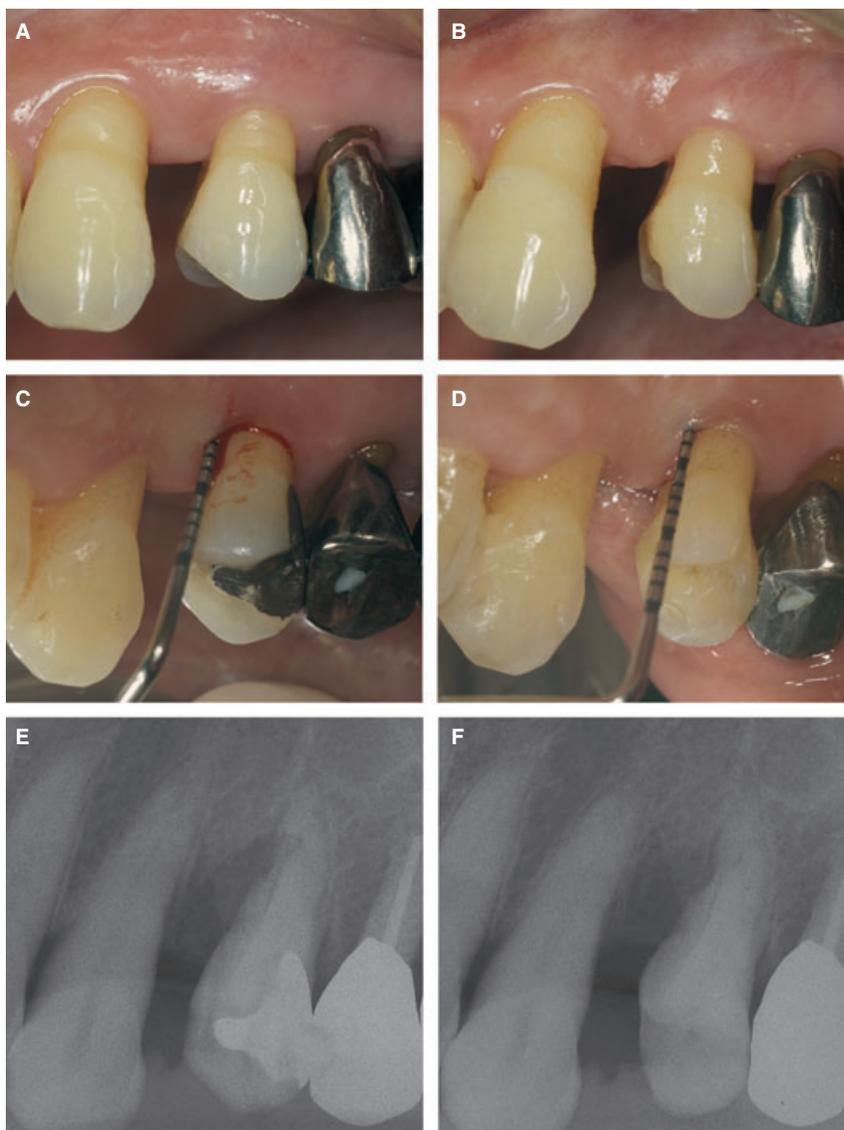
Clinical and radiographic pictures of the Er:YAG laser-treated sites before (A and C) and after (B and D) the surgery shown in Fig. 7. Probing pocket depth before surgery at the linguo-mesial site of the upper-left premolar was approximately 7 mm with bleeding on probing (C) and decreased to 2 mm without bleeding on probing at 12 months following surgery (D). Although slight gingival recession was observed 12 months after surgery in comparison to before therapy, 4 mm of clinical attachment gain was obtained. No complications or side effects were clinically observed. The vertical bone defect observed before surgery on the mesial site (E) was repaired by bone regeneration following laser surgery. No adverse side effects were observed in the irradiated bone tissue (F) (case by: A. A.).
